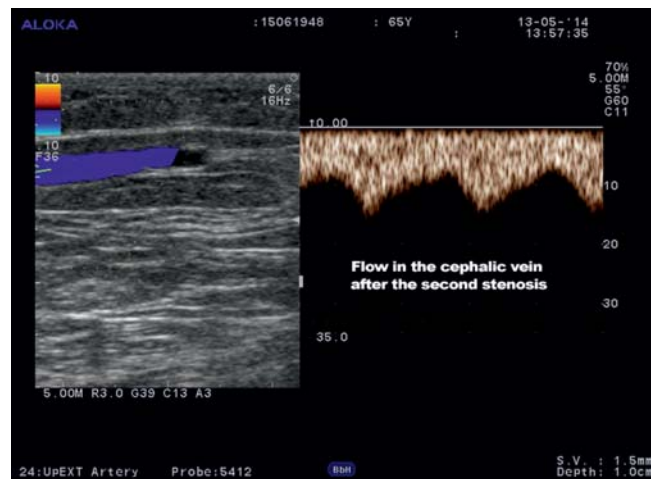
Color Doppler ultrasound of the cephalic vein after the second stenosis.
